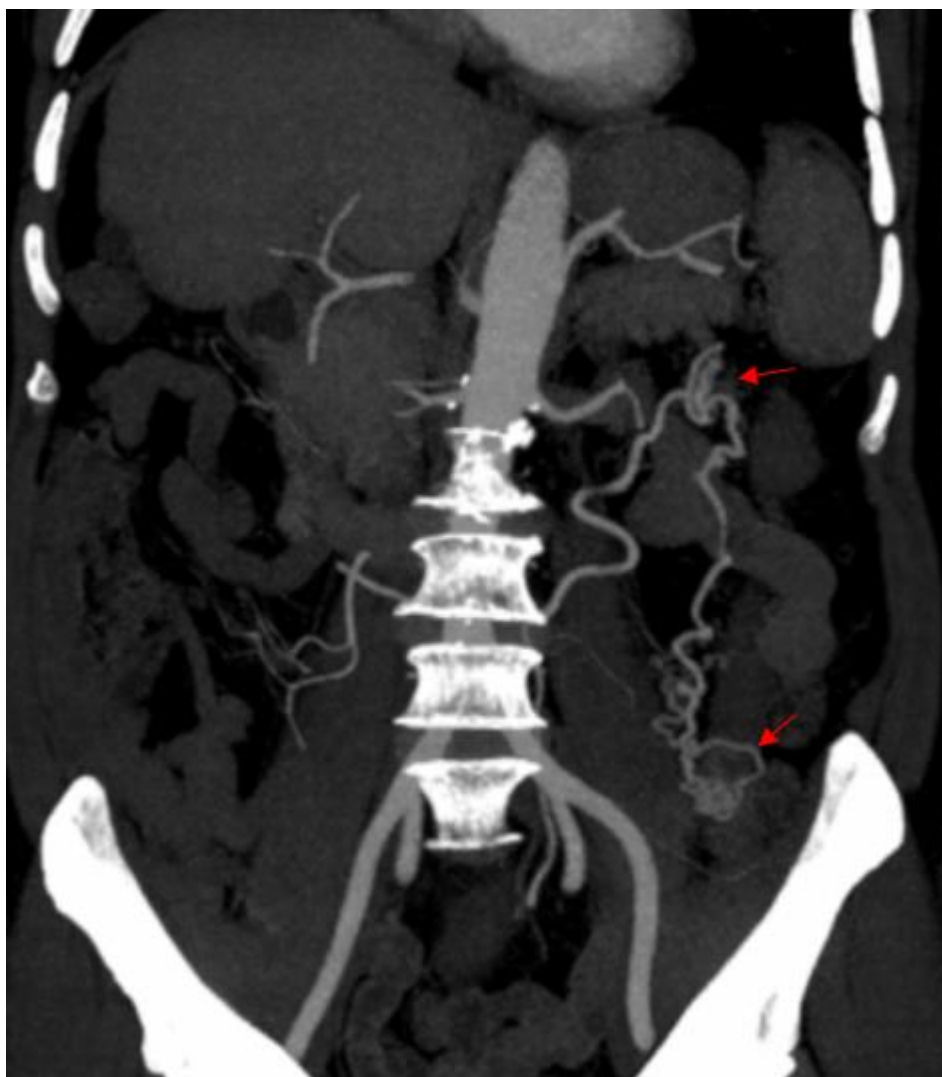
Coronal maximum intensity projection (MIP) CT angiographic reconstruction demonstrating the anatomical extent of the vascular malformation and the distribution of tortuous abnormal vessels along the left colon and rectosigmoid junction (red arrows).
